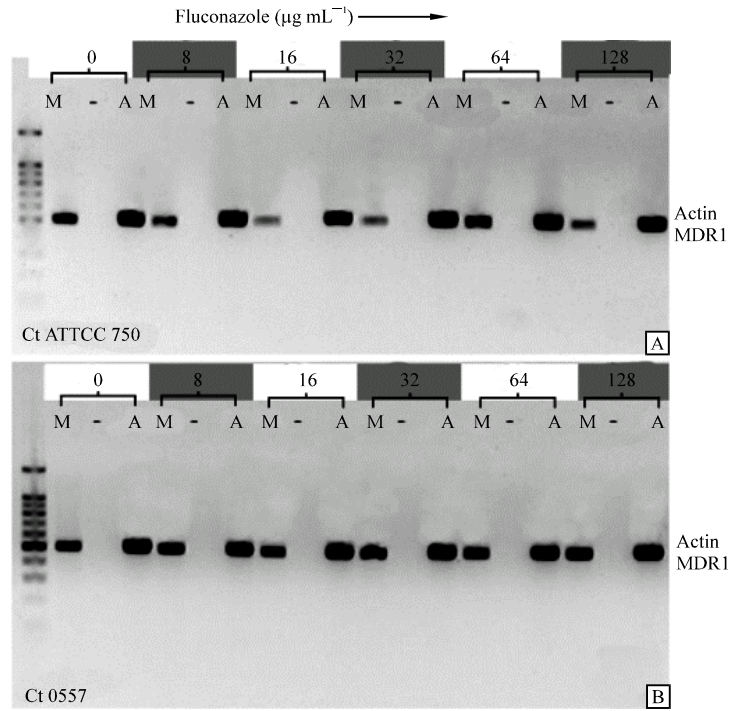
RT-PCR analysis of CtMDR1 and Actin genes for drug susceptible *Candida tropicalis* CT ATCC 750 (A) and drug resistant isolate Ct0557 (B) after induction with different fluconazole concentrations. ['M' = MDR1, '-' = without MMLV reverse transcriptase, 'A' = Actin]
